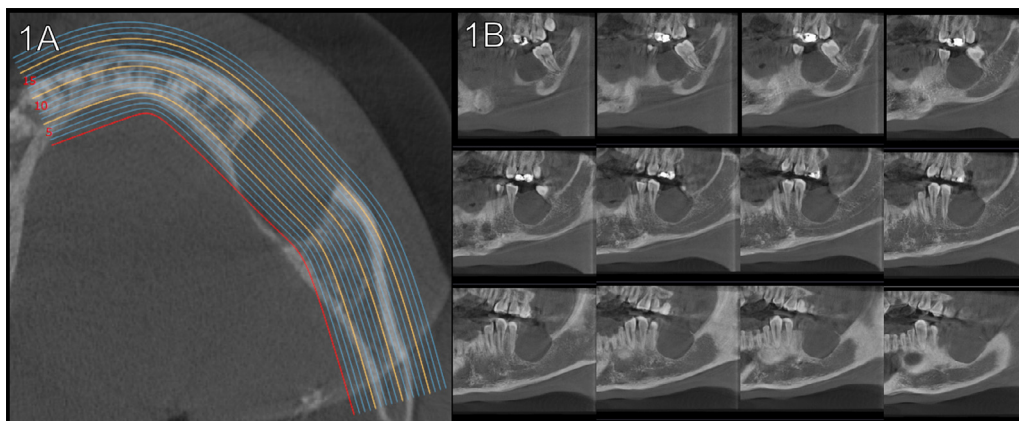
Representative scheme of the evaluation in cone beam computed tomography (CBCT). An axial slice (A) in which a panoramic curve was generated and the subsequent panoramic reconstruction images (B) assessed with minimum slice thickness and 1 mm interval between slices. In this case, the inferior periphery of the lesion presents a continuous cortication.
